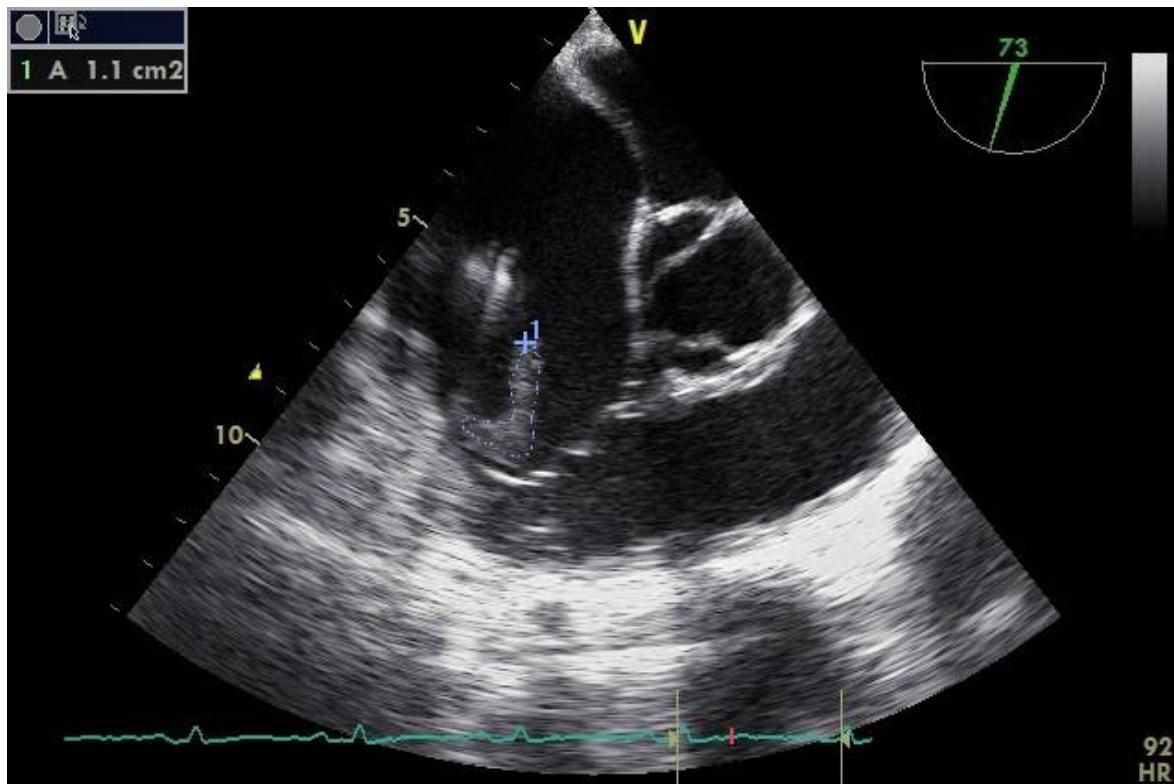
Transesophageal echocardiography shows a noticeable decrease in the size of the mass.
